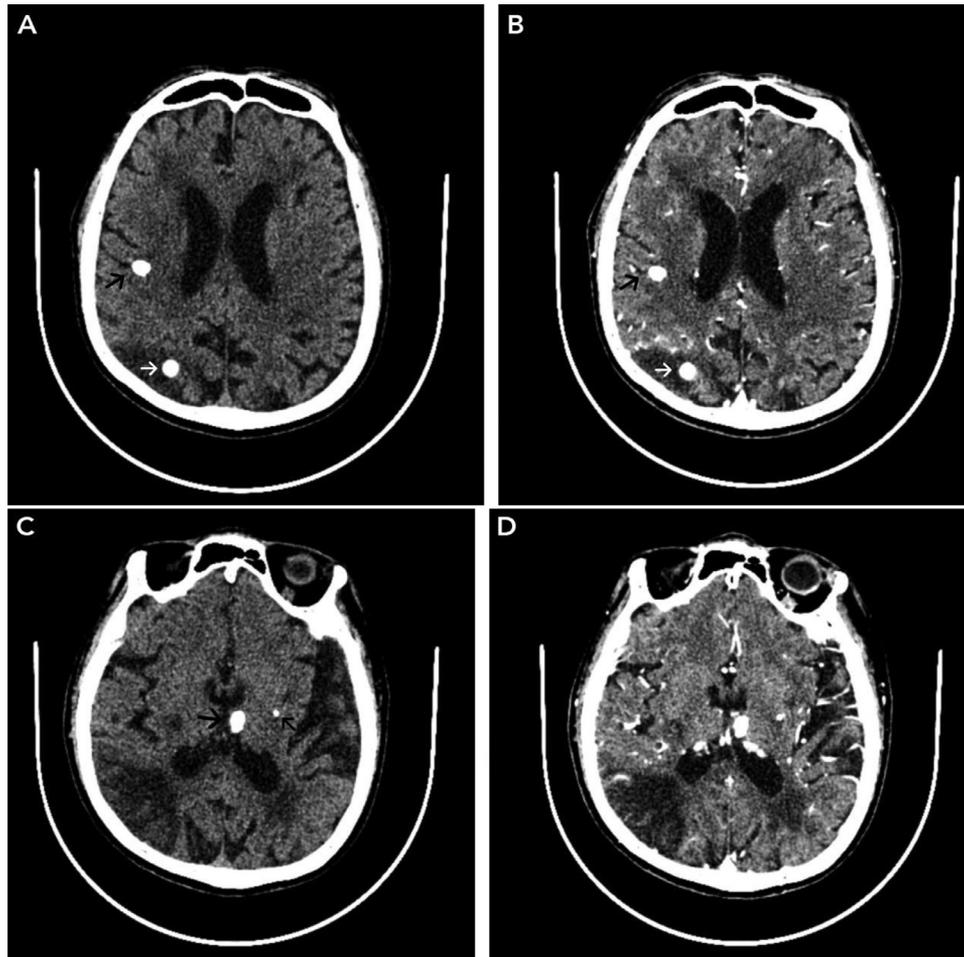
Axial view CT scan without contrast (A, C) and with contrast (B, D) showing multiple calcified nodule with well-defined border at right subcortical parietal lobe, left thalamus, and left basal ganglia, with the largest diameter of 1.20 cm at left thalamus, characterizing nodular calcified stage (black arrow). There is also a calcified nodule with well-defined border, and diameter of 0.90 cm at right cortical-subcortical occipital lobe (white arrow). There was hypodense lesion surrounding the lesion that resulted in narrowing of surrounding sulci and gyri suggesting surrounding vasogenic edema characterizing granular nodular stage. No enhancement was seen at postcontrast scanning.
